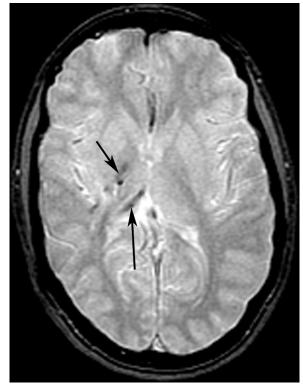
Axial GRE MRI (TR/TE, 700/15 milliseconds) demonstrates magnetic susceptibility-related signal loss in the posterior limb of the right internal capsule (short arrow) and the right thalamus (long arrow).
